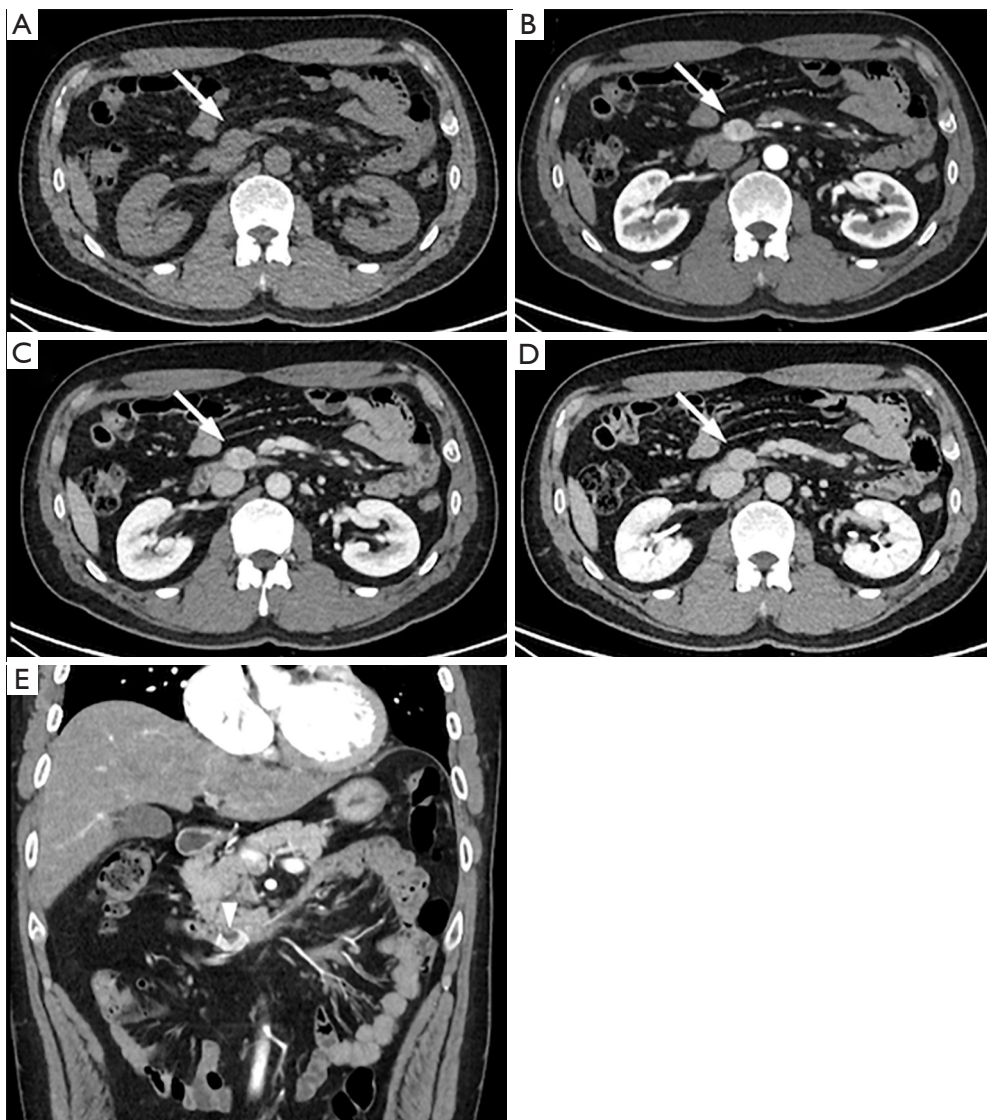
Computed tomography of the duodenal glomus tumor. Axial unenhanced computed tomography (CT) scan (A) shows a well-circumscribed mass (arrow) in the third portion of the duodenum. Contrast-enhanced CT scans reveal strong enhancement in the arterial phase (B) and persistent enhancement in the portal (C) and delayed (D) phases (arrows). Coronal arterial phase CT scan (E) demonstrates central ulceration (arrow head).
